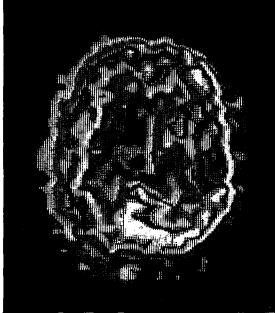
A case of the large infarct with positive Tc99m-HMPAO SPECT and negative CT: 54 years old man came to ER with rapidly progressive left hemiparesis and memory disturbance on first day after attack. XCT was normal as seen on fig 4(B) and Tc99m-HMPAO SPECT exhibited the large perfusion defect in DPA more than 30% in rt. hemisphere as seen on fig 4(A-1). Vertex slice shows irregular hypoperfusion
